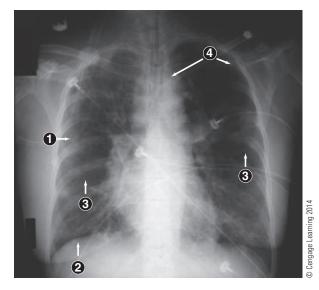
Status asthmaticus. Hyperinflation is evident on this chest radiograph since the distance between the adjacent ribs in widened (1) and the diaphragm is depressed (2). Infiltrates or areas of edema are noted (3). The central venous line (4) is also visible on this chest radiograph.
